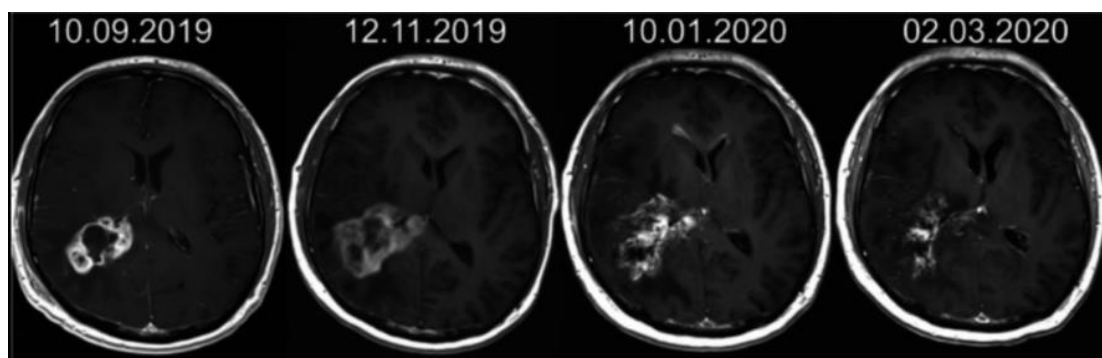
MRI images of a 42-year-old man diagnosed with recurrent glioblastoma NOS manifested 10 months after surgery and standard radiochemotherapy. The patient was treated with three cycles of 30-MBq ^{225}Ac -DOTA-SP with a total activity of 90 MBq. The T1-weighted enhanced MRI image before treatment and in follow-up presented shrinkage of the tumor.
